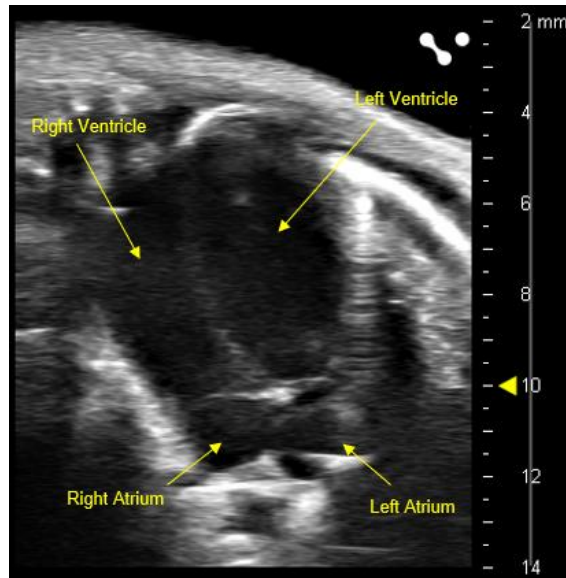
Representative apical 4 chamber view
